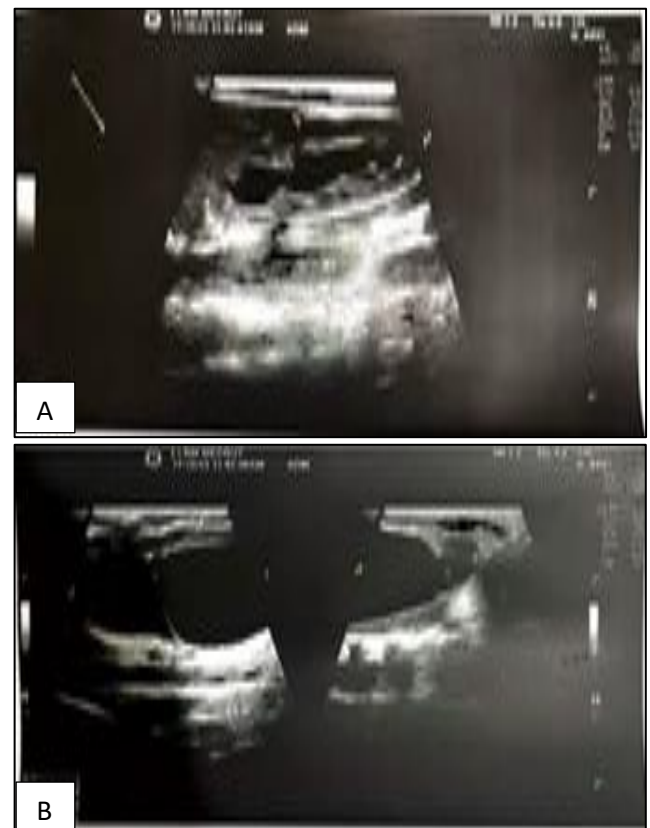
(A and B): Ultrasonography suggestive of gross hydronephrosis, renal parenchyma thinning, and undescended testis.
